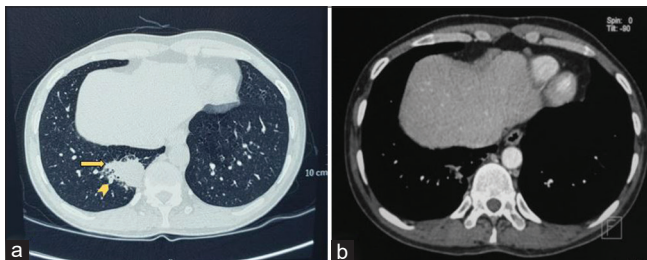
(a) Pretreatment computed tomography of the chest revealing a heterogeneously enhancing mass (arrow) with multiple calcific nodules surrounding the lesion (arrow-head). (b) Posttreatment follow-up computed tomography chest after 1 month
